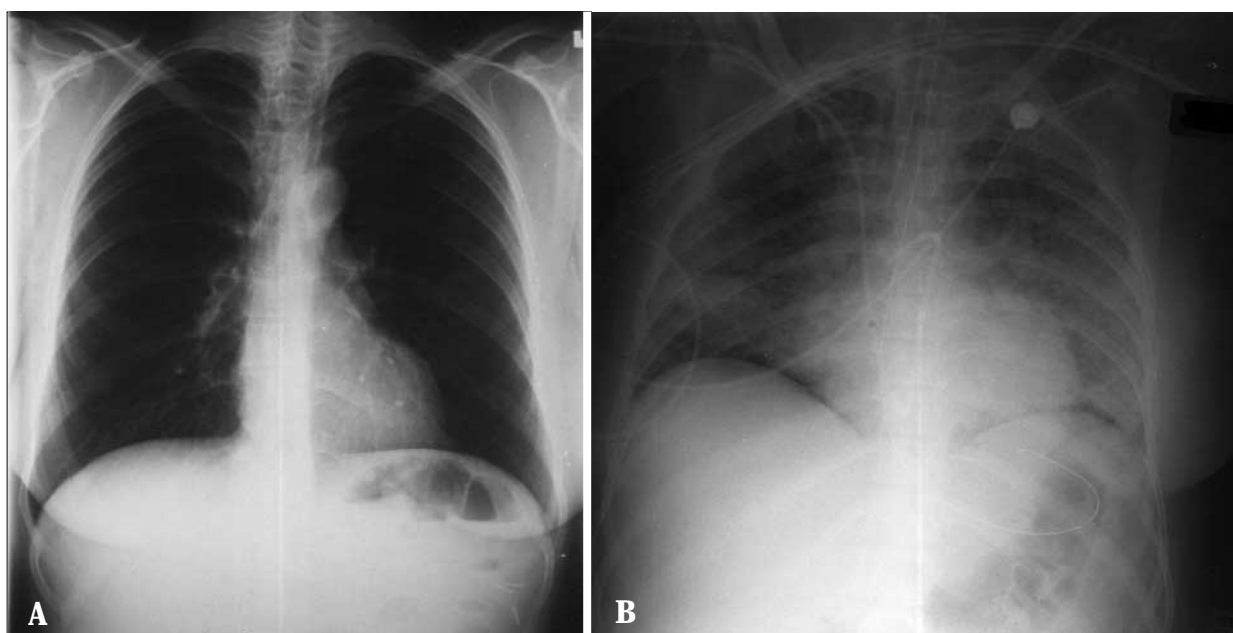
Chest radiographs on admission to the hospital (A) and when diffuse, bilateral airspace infiltrates developed (B).
